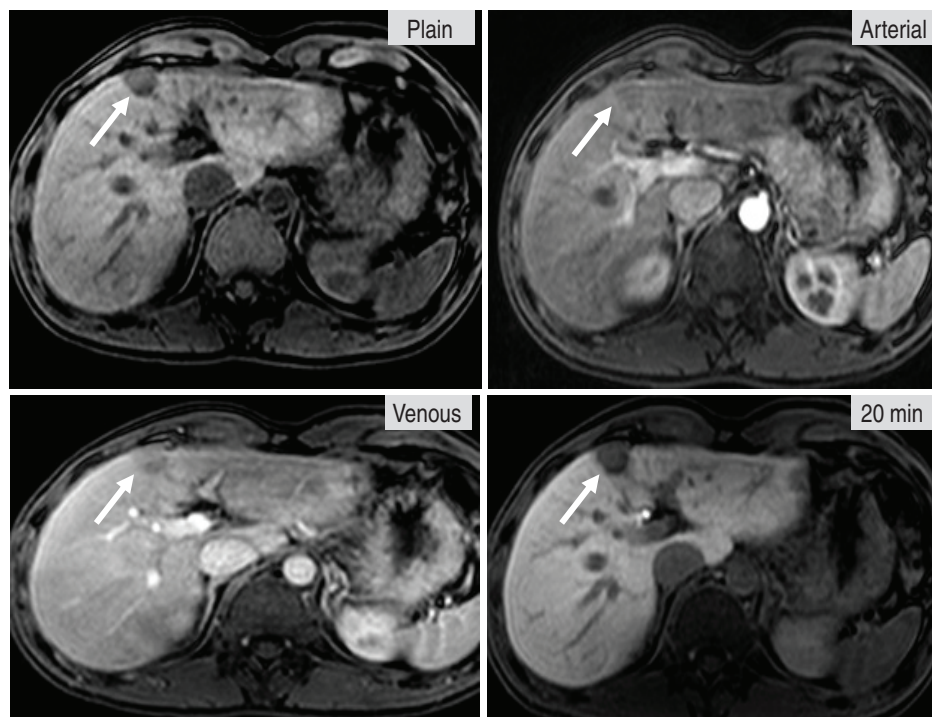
A 2 cm hypovascular HCC in a patient with chronic HBV. MRI with EOB-primovist contrast agent shows a hypovascular nodule, which is atypical for HCC. Because of its atypical pattern, tissue biopsy is required to confirm the diagnosis.
